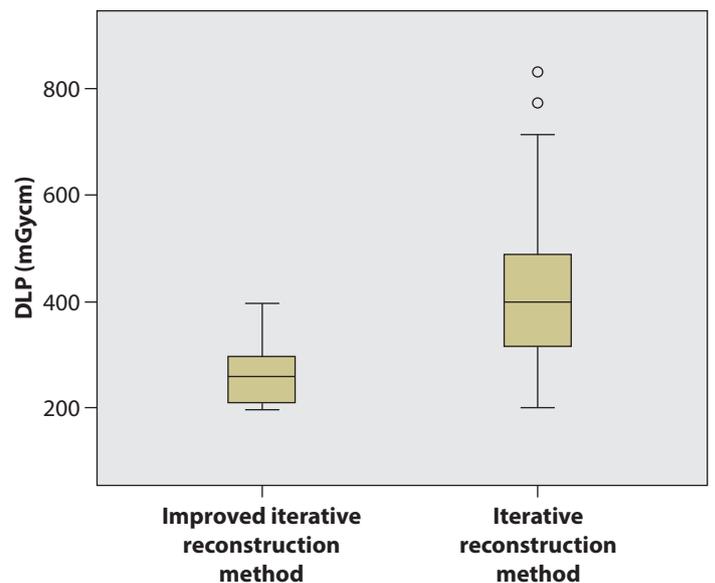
Comparison of the DLP in the standard PET/CT protocol before and after the improved iterative reconstruction method
